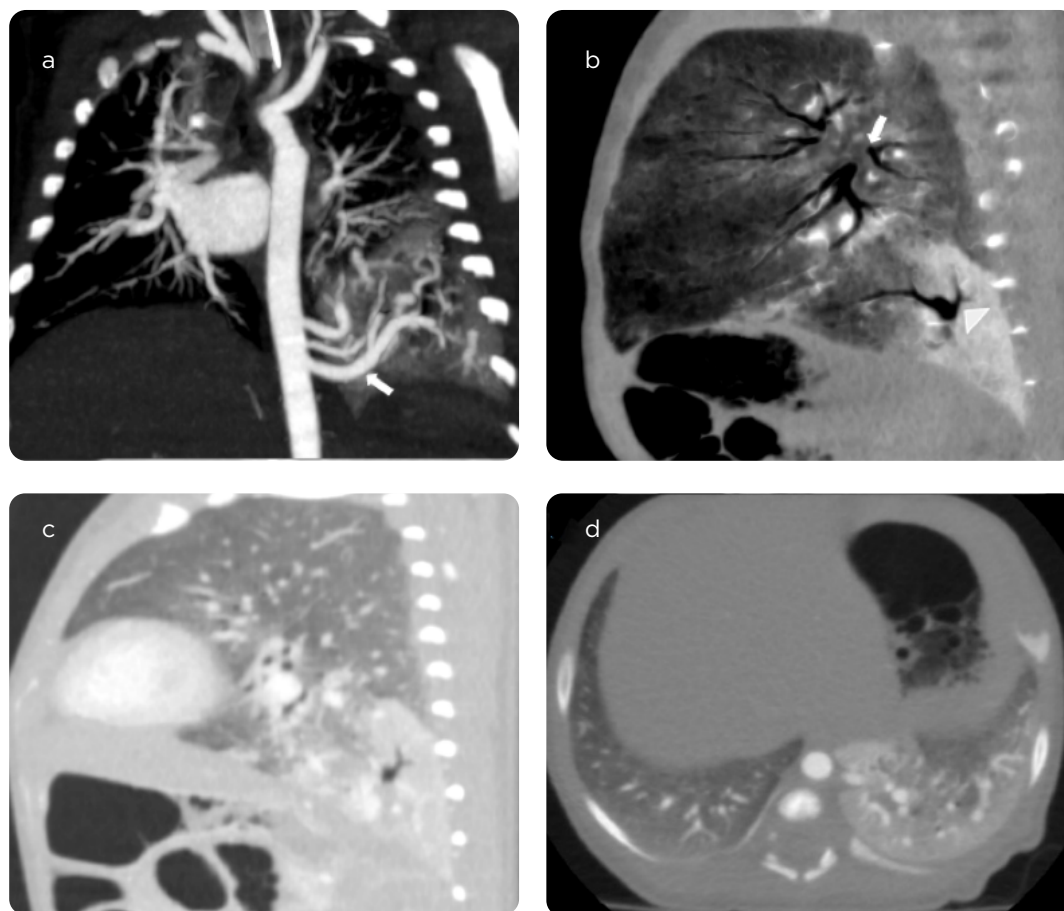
Chest CT with contrast medium, acquisition in arterial phase. a) Coronal reconstruction in maximum intensity projection. Shows the three aberrant arteries originating in the descending aorta (arrow). b) Sagittal reconstruction in minimum intensity projection, showing absence of communication of the sequestration (arrow) with the bronchial structures (arrow head). c) Sagittal reconstruction. d) Axial in lung window: area of consolidation in the basal segments of the left lower lobe, well delimited, with bronchial structures in its interior without connection with the bronchial tree.
